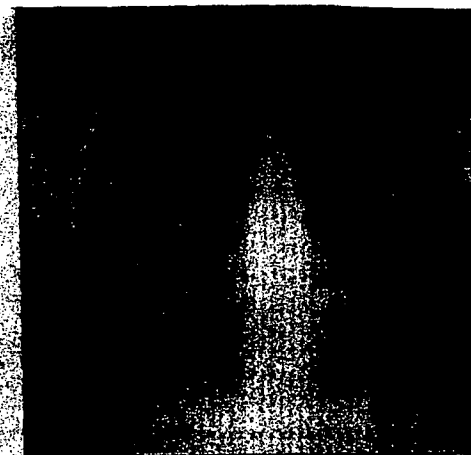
J.W. Age 49, 1975. Truck driver until 1960, when he became "pipe coverer" in a shipyard. X-ray, fifteen years later, shows reticular (irregular) opacities of moderate profusion (2/2 in the ILO U/C Classification). Some shortness of breath on exertion. Note: infiltrate in lower lung fields, upper lobes clear. This is common.
